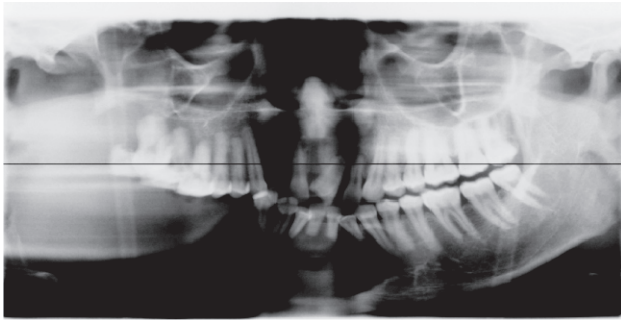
An orthopantomogram which shows a radiolucent left mandibular lesion, extending from the head of the condyle (arrow 1), to the apical region of 44 (arrow 2). The roots of 31, 32, 33, 34, 41 and 42 are truncated.
